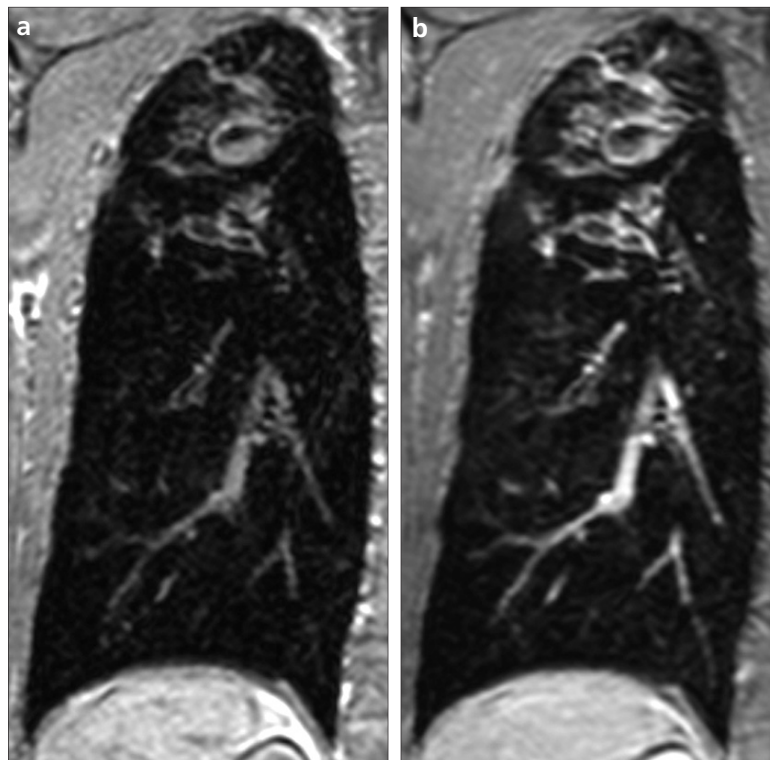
a, b. A 43-year-old patient with cystic fibrosis. Coronal T1-weighted three-dimensional gradient echo sequence (a) shows severe bronchiectasis, bronchial wall thickening, and mucus plugging predominantly of the right superior lobe of the lung. The repetition of the sequence after the administration of contrast media (b) allows for the differentiation between inflammatory wall thickening and mucus content within bronchi. Courtesy of M. Eichinger and M. Puderbach, Heidelberg Thoracic Imaging Platform, Heidelberg, Germany.
